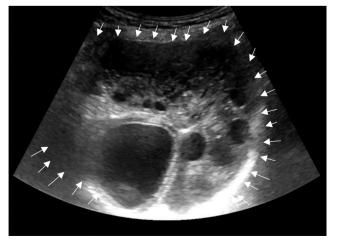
Multiloculated cystic lesion on USG (little white arrows) USG: Ultrasonography
